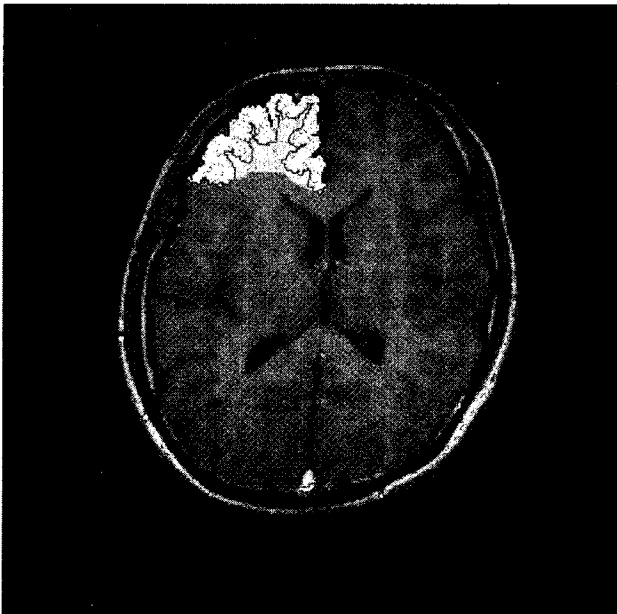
A representative image of ROI on SE T1-weighted image. GM and WM of frontal lobes were selected as ROI
